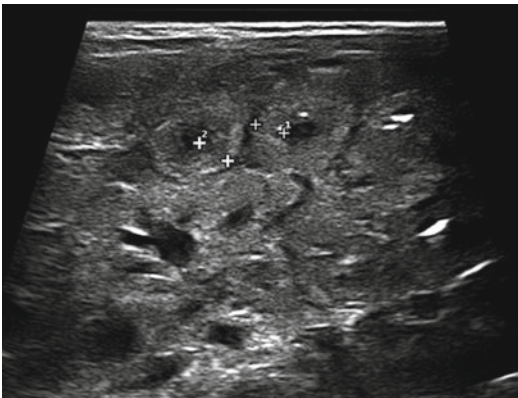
Ultrasound in newborn, with early state of NEC, shows the thickened wall bowel; note the slight hyperechogenicity of the intestinal wall (*white arrow*)
